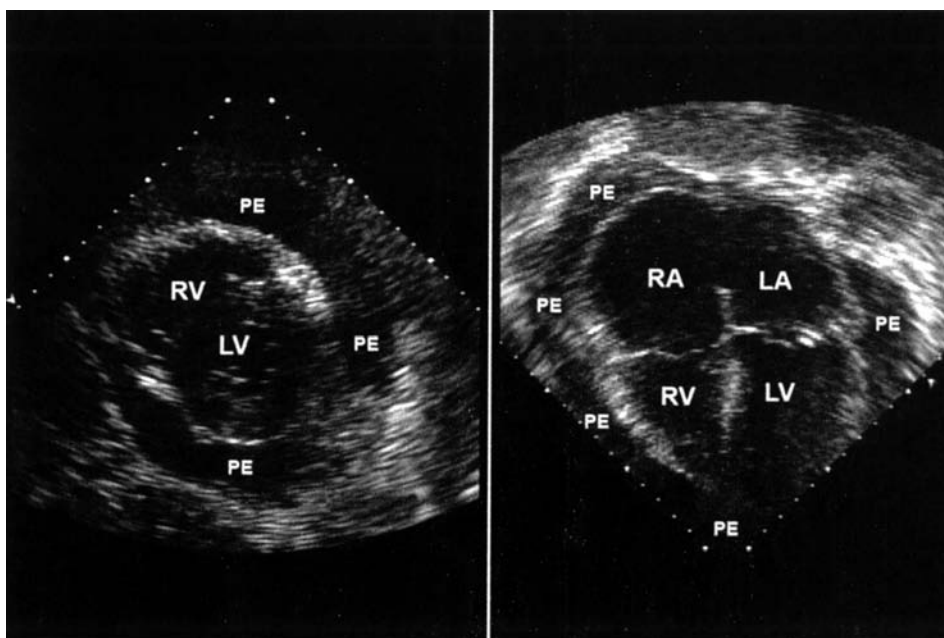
Echocardiographic image of a moderately sized circumferential pericardial effusion (PE). The patient had mild tamponade physiology according to echocardiography or Doppler criteria. Left panel. Parasternal short axis view of the heart. Right panel. Apical 4-chamber view of the heart. LA: left atrium; LV: left ventricle; RA: right atrium; RV: right ventricle.
